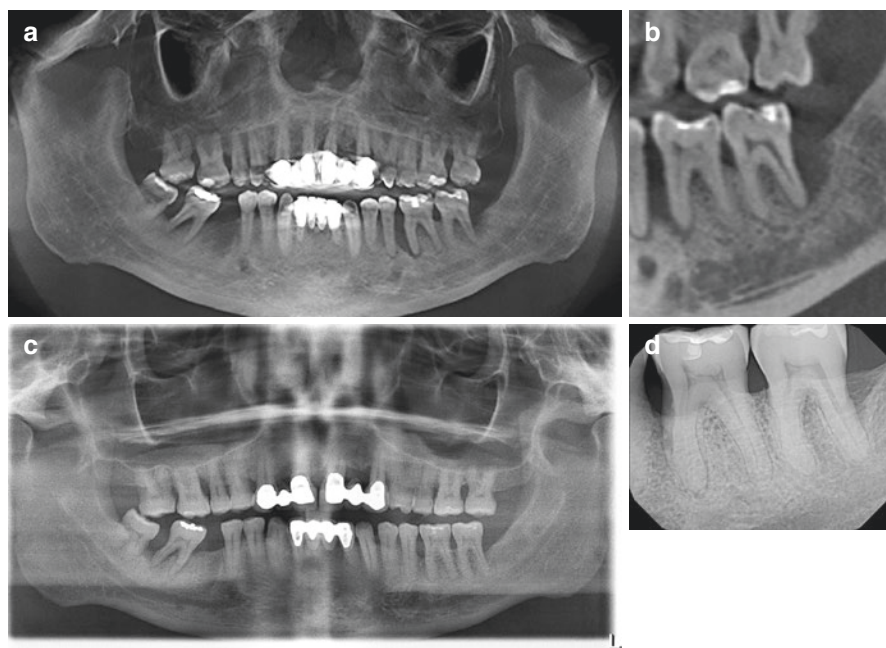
Clinical application of digitally pulsed Nd:YAG laser for periodontitis treatment. The patient was 41-year-old male who was seen for treatment of advanced periodontitis (a and b). Probing showed generalized non-maintainable pockets. The pretreatment radiograph showed vertical bone loss and horizontal bone loss. The LANAP procedure was performed. After treatment he was put on a 3-month periodontal maintenance schedule. The 70-month post-LANAP treatment view showed no loss of any dentition. The 8.4-year follow-up showed long-term bone regeneration stability (c and d)
